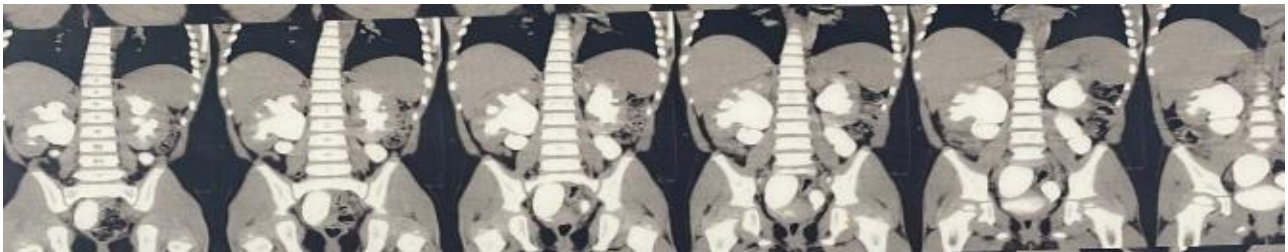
CT scans show marked bilateral hydronephrosis grade IV bilaterally with tortuous dilated megaureters
